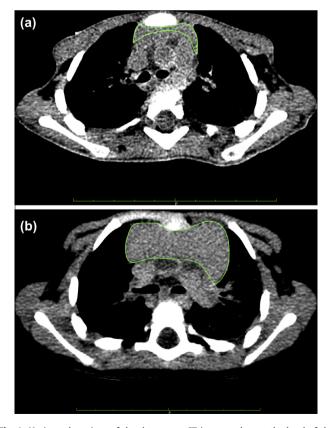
Horizontal sections of the thymus on CT images taken at the level of the carina. The green line indicates the thymic border and a region of interest. (a) A 10-month-old female with thymic involution (Case No. 17 in Table 1). (b) A 12-month-old male without thymic involution (Case No. 18).
